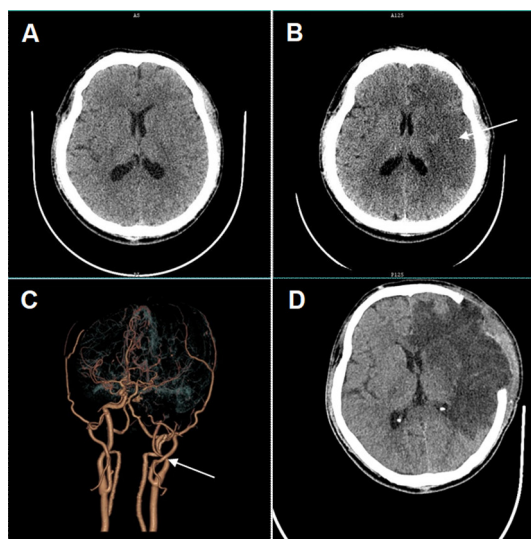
Head CT scan: pre-IVT injection (A); 24 hours post-IVT, showing a large left hemisphere infarction (B) and left internal carotid artery occlusion (C); post-decompressive craniectomy (D).
